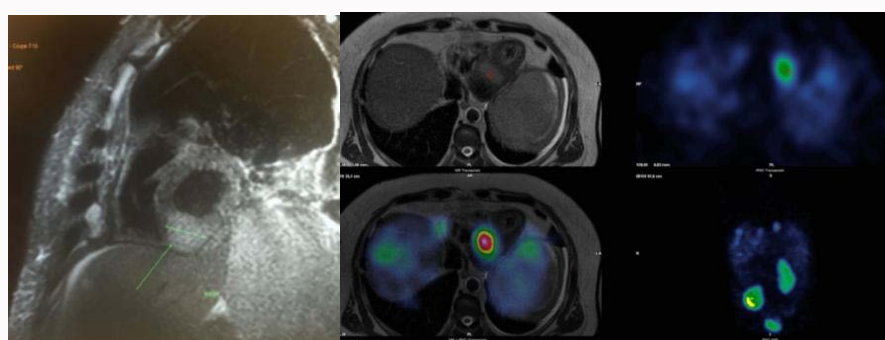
Myocardial MRI (T2stir sagittal) and fusion images of SRS SPECT with MRI: gadolinium enhancing lesion of 24 mm in the myocardial inferior wall.
